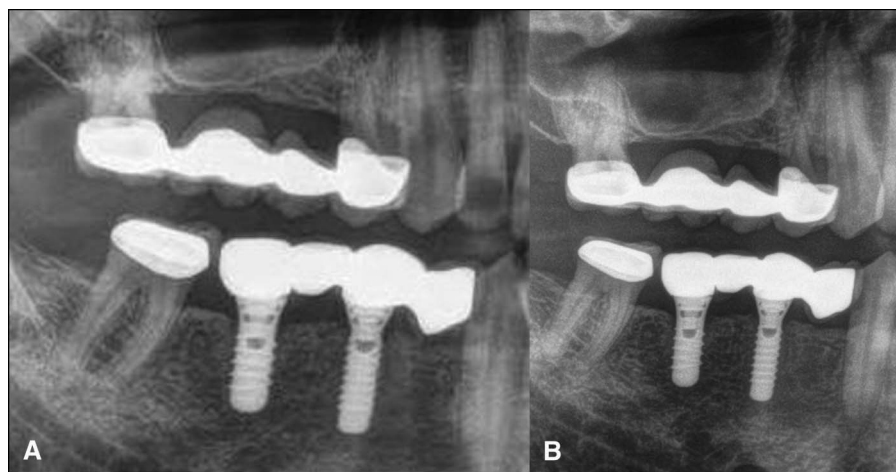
A and B, Radiographs of SLActive implants after a mean observation period of (A) 21-month follow-up period and (B) 82-month follow-up period. Note the marginal bone loss after 82 months in Figures 3B and 4B.
